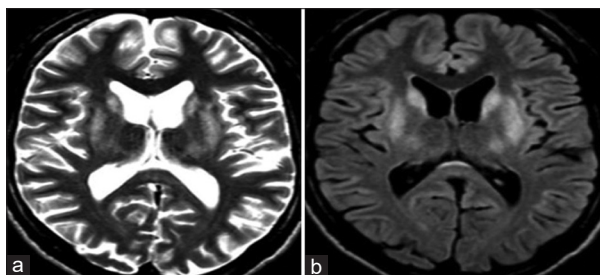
Hyperintense changes localised in the putamen, head of the nucleus caudate and thalamus in T2-weighted sequences (a) and fluid-attenuated inversion recovery (b)
